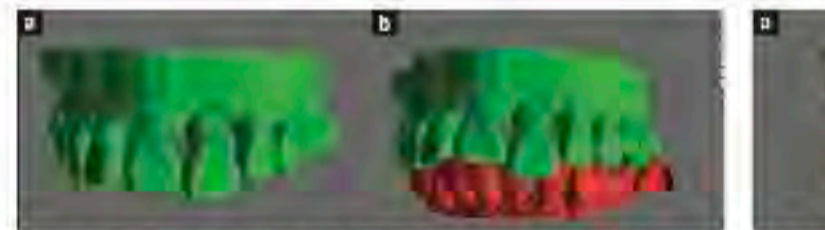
To complete the planning process, the diagnostic waxup or virtual tooth sets of the desired restorative outcome was applied to the CBCT surface DICOM data in order to determine the potential implant placement.
